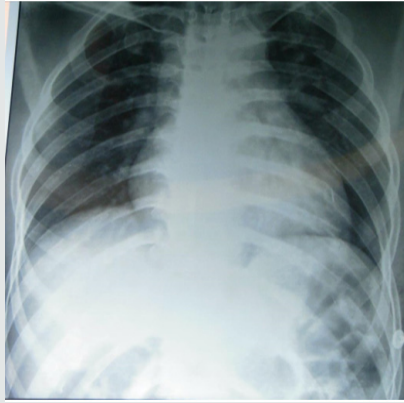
Anteroposterior radiograph of the chest demonstrating fracture of 3rd to 11th ribs.
